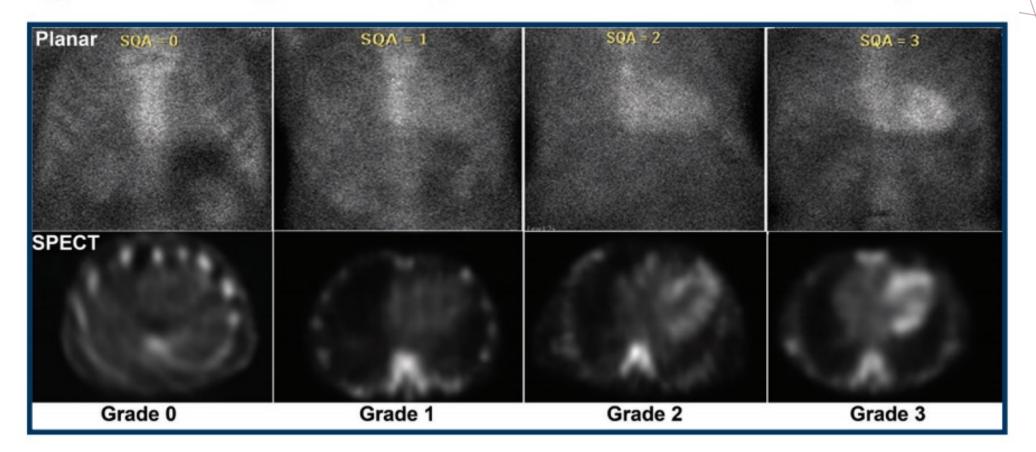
Grading 99mTc-PYP Uptake on Planar and SPECT Images
